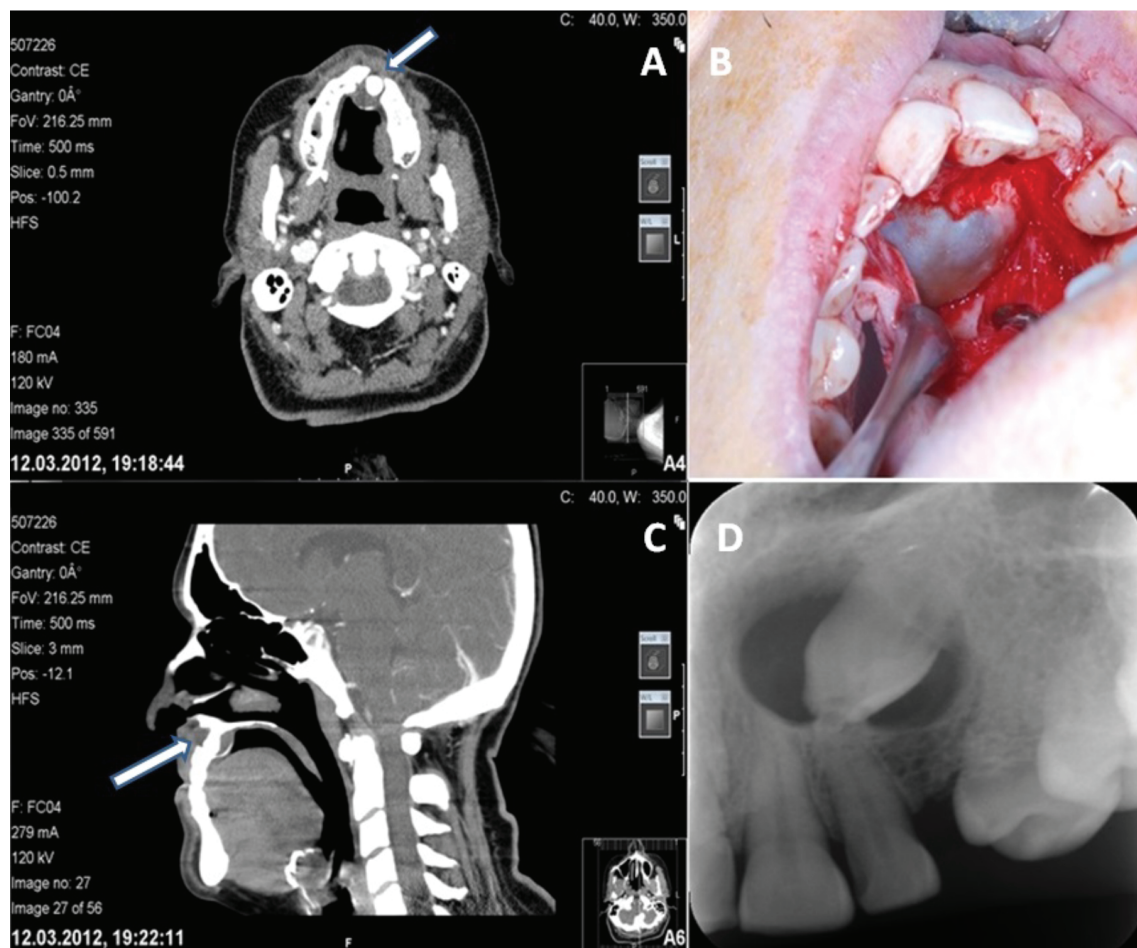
A: Transversal view of CT before surgery, B: Sagittal view of CT before surgery, C: Intraoperative view, D: Periapical radiograph before surgery.
